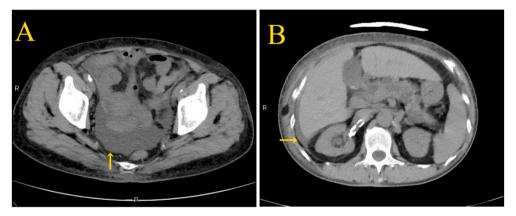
Abdominal computed tomography scan. (A) Minimal ascites was observed. (B) There are hepatic atrophy and minimal ascites on the surface of the liver.
